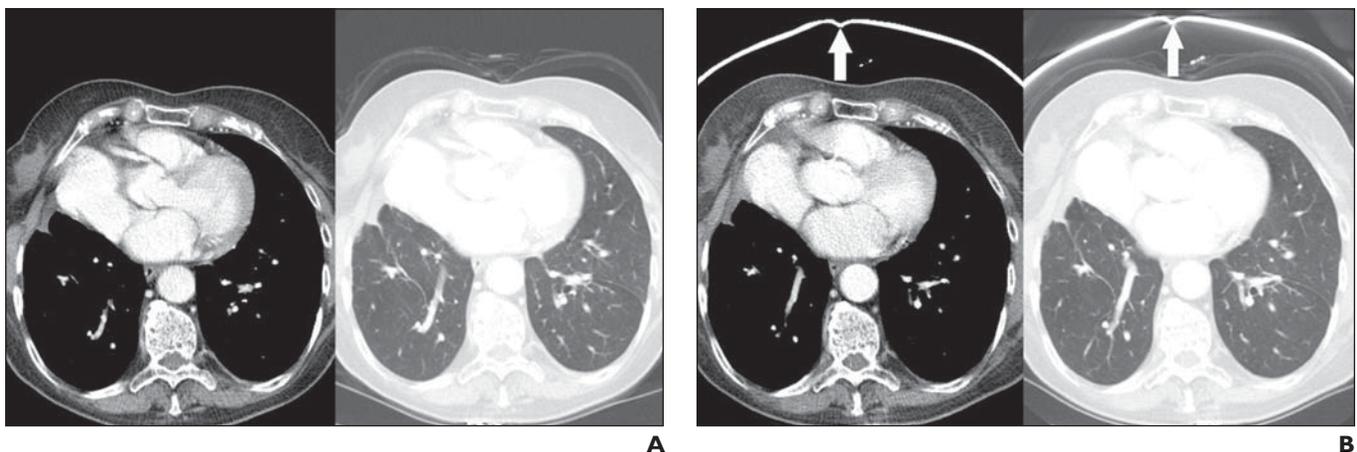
75-year-old woman with history of right partial lung resection for cancer. A, Photomontage of axial contrast-enhanced CT images of chest are displayed in soft tissue and lung windows. B, Photomontage of corresponding images from subsequent CT obtained with bismuth shield (*arrows*) over breasts shows diagnostic quality of study unchanged, but dose to breast significantly reduced.
